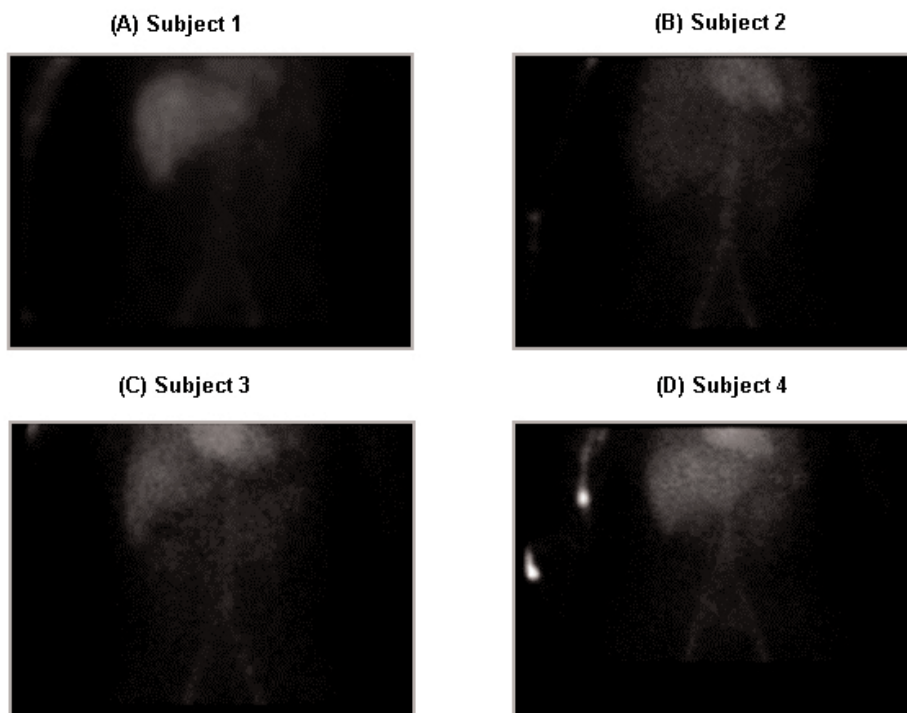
Animated gamma scintigraphic images of Tc-99m mebrofenin disposition (from 0 to 180 minutes). Clicking on each panel will initiate animation: A, subject 1; B, subject 2; C, subject 3; D, subject 4. Hepatic uptake of Tc-99m mebrofenin was rapid, followed by excretion into the canalicular space and accumulation in the gallbladder. Gallbladder contraction, facilitated by an IV infusion of cholecystokinin-8 at 120 minutes, resulted in expulsion of bile containing Tc-99m mebrofenin from the gallbladder into the duodenum and subsequent aspiration via the oroenteric tube. (Animation available online only.)
